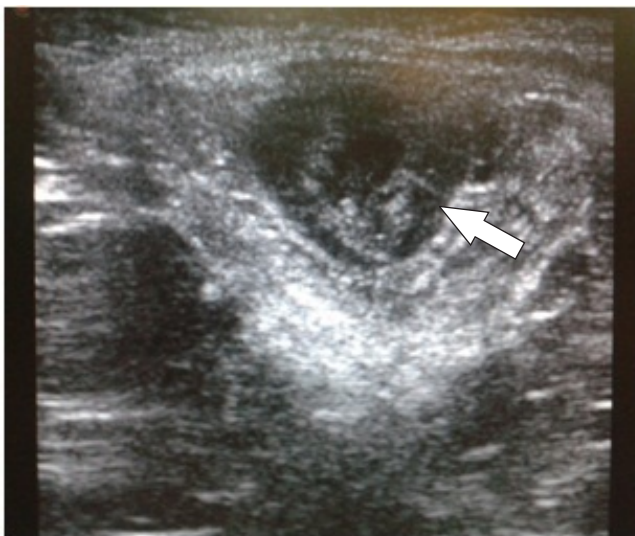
Ultrasonographic view of the puborectalis muscle (arrow)
